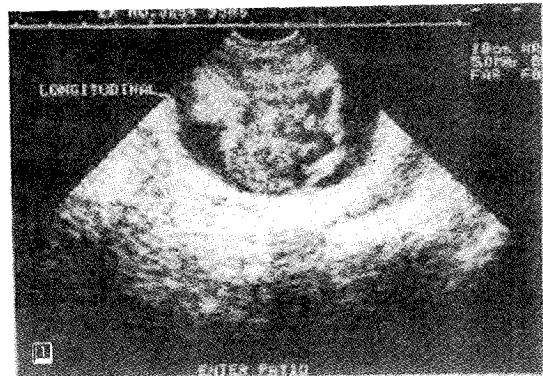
Sonography of the left testis showing lobulated enlargement
